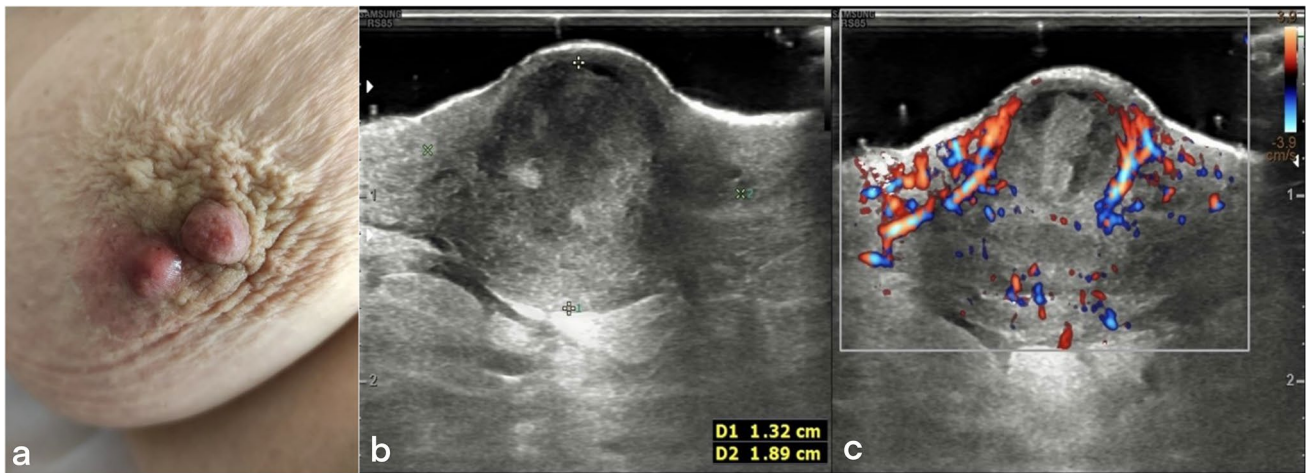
a abscess of the montgomery's gland. b US image shows a heterogeneous hypoechoic intradermal collection compatible with an abscess with increased peripheral color-Doppler signal (c)
